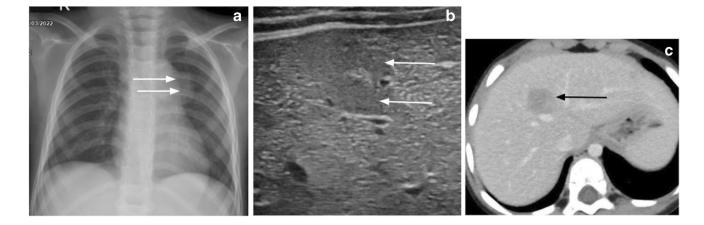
Phaeohyphomycosis. The same patient as in Fig. 6. The child developed cough and abdominal distension a few days after presentation. On investigation, elevated leukocyte count was found with eosinophilia. a Frontal radiograph showed mediastinal lymphadenopathy along the left heart border (arrow). b Axial section of US
